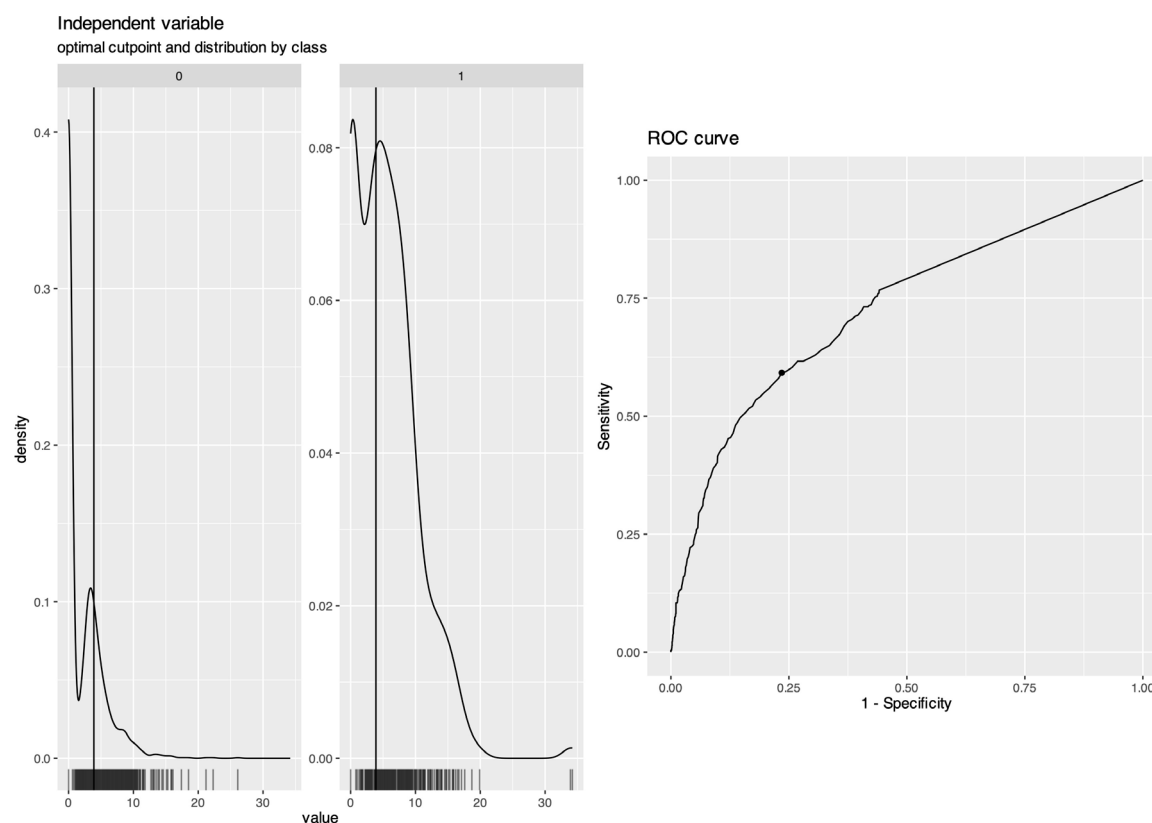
Optimal cut point of univariate MLN SUVmax in predicting pathological N2 status. MLN, mediastinal lymph node; ROC, receiver-operating characteristic curve; SUVmax, maximum standard uptake value.
